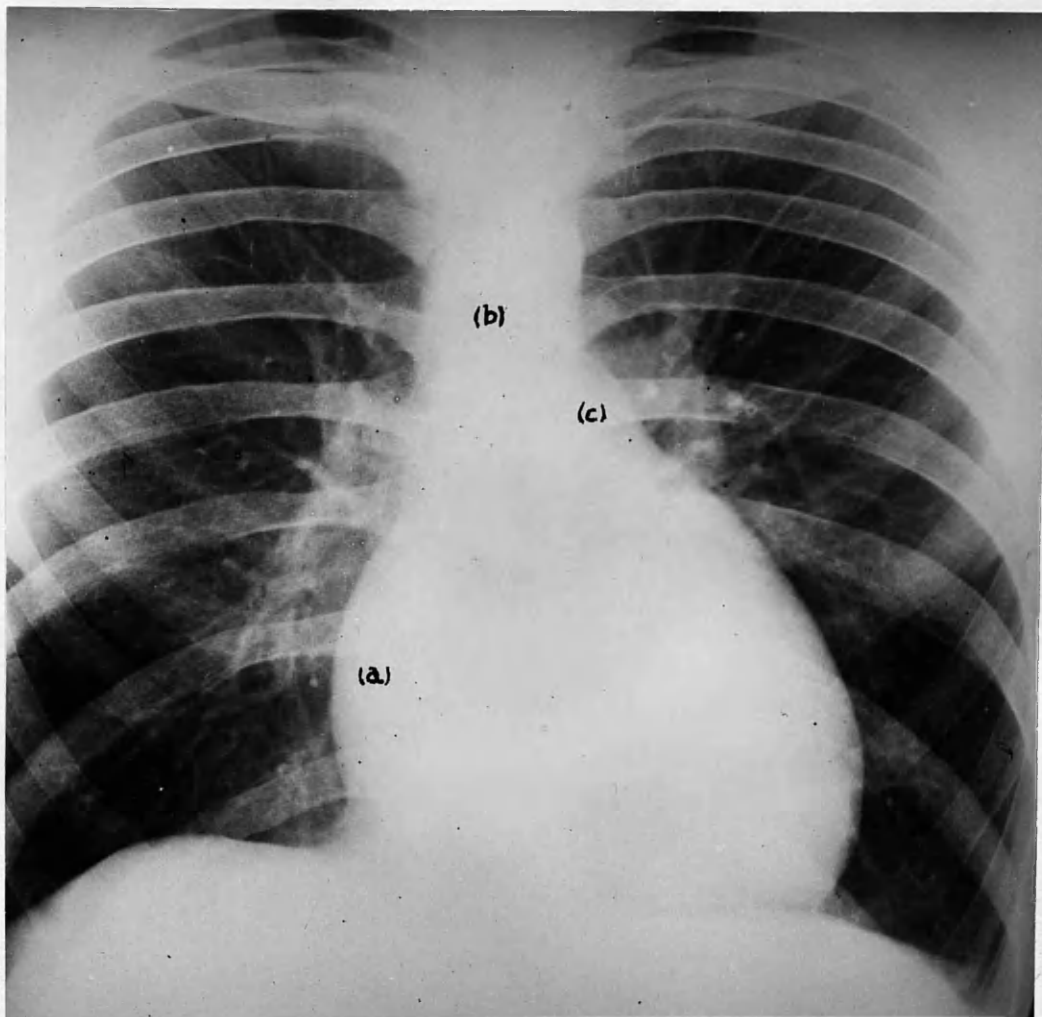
The chest radiograph, in this case of the argentaaffinoma syndrome, shows at (a) the enlargement of the right side of the heart, at (b) the small aortic knuckle, and at (c), the visibly dilated pulmonary conus.
